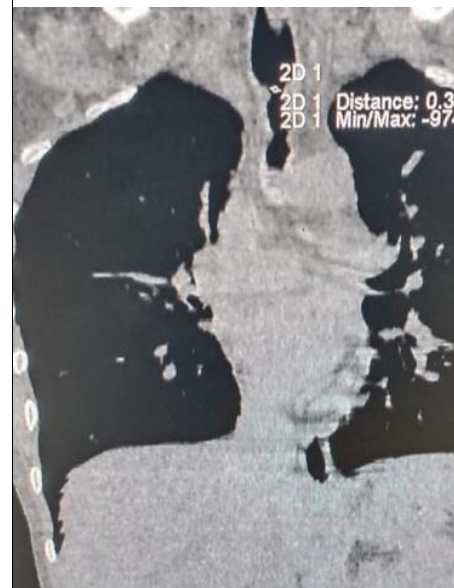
HRCT with short segment tracheal narrowing in the subglottic region at the level of D2-D3 measuring 4 mm at the narrowest portion opposite D2 level
